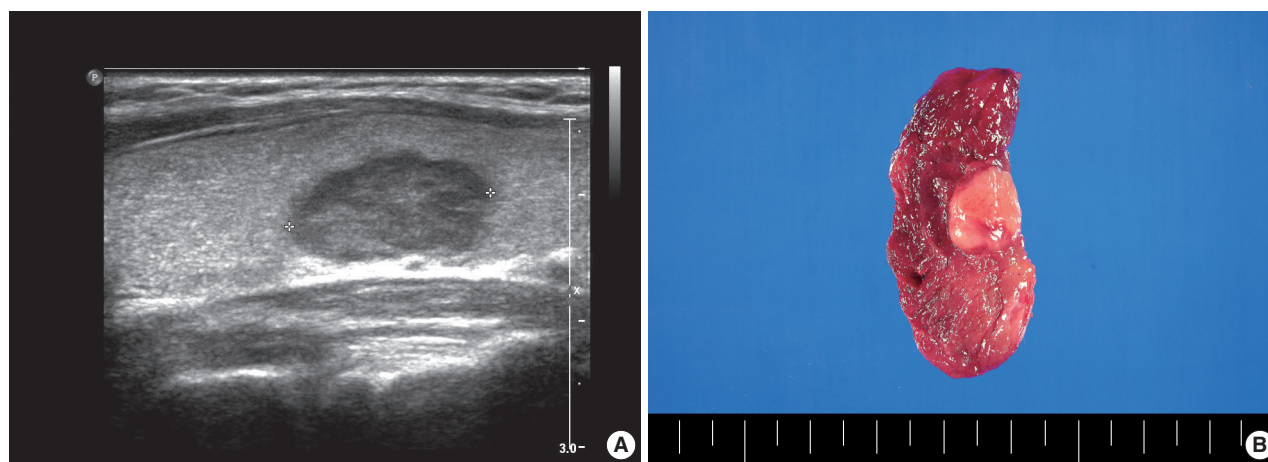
Ultrasonography shows a well circumscribed, hypoechoic, hypervascular mass with heterogeneous echogenicity in the right lobe of the thyroid (A). Cut surface reveals a well defined, pinkish-gray, solid mass, measuring 1.6 × 1.2 × 0.7 cm (B).
